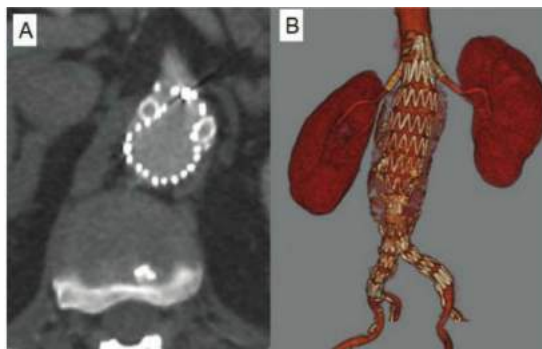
• A. Postoperative CTA axial view showing molding of main body endograft around two widely patent snorkel stents. B. 3-D reconstruction demonstrating excellent perfusion of both kidneys and no evidence of endoleak.
